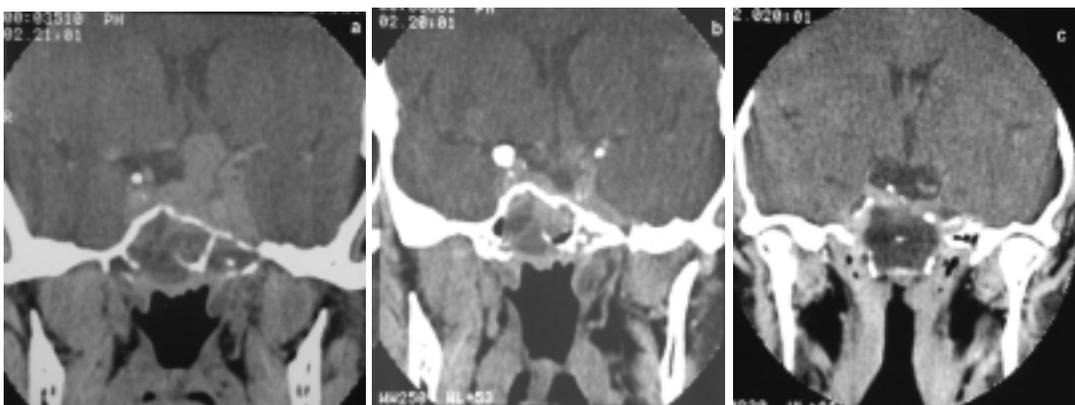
CT scan of a resistant macroprolactinoma before the beginning of DA therapy (a); two years later, after treatment with BRC 30 mg/day+CAB 7mg/w- shrinkage 30% (b); two years after radiotherapy and under BRC 30 mg/day - tumor remnants with necrotic changes (c).
